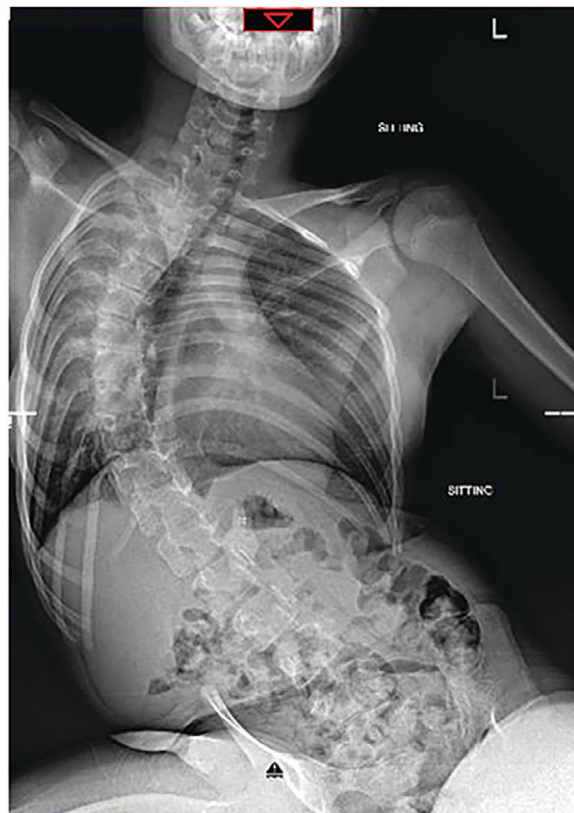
Sitting radiographs spine
